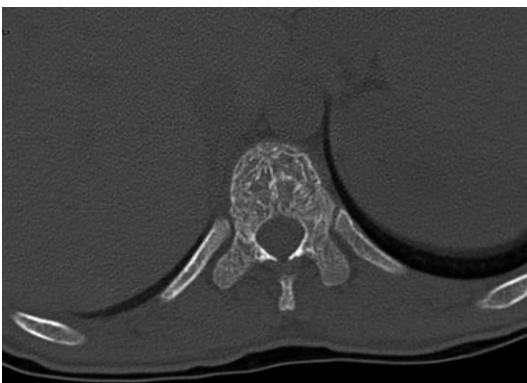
Pre-operative "bone window" computed tomography scan without contrast media: the vertebral body is devoid of bony erosion and has a lacey appearance.
